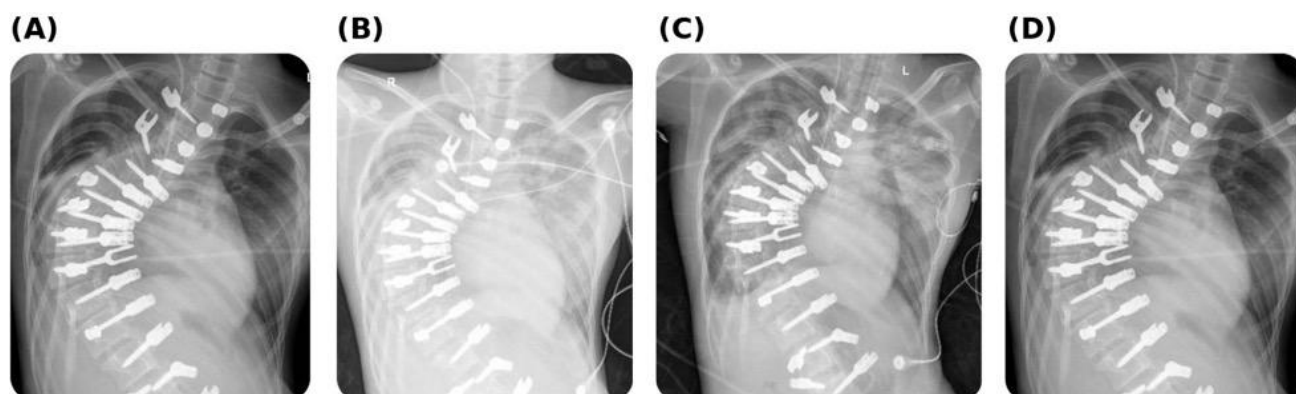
Serial anteroposterior chest radiographs of Case 1 during the intensive-care course, showing the posterior spinal instrumentation from scoliosis correction. (A) At the onset of post-transfusion acute respiratory distress with dense bilateral infiltrates (PaO₂/FiO₂ 72). (B) Early post-onset film with partial clearing (PaO₂/FiO₂ 134). (C) Intensive-care day 3 with further resolution (PaO₂/FiO₂ 180). (D) Intensive-care day 5 with near-complete clearing of the infiltrates (PaO₂/FiO₂ 343). Laterality markers (R, L) are the only annotations; no patient-identifying information is present.
